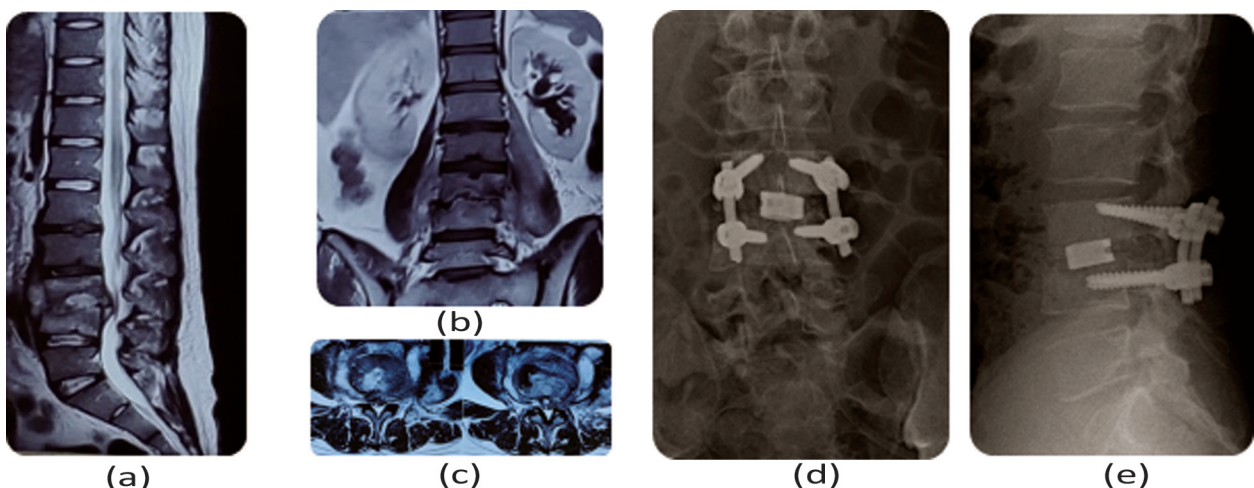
(a, b, and c) shows T2-weighted MRI images of the L3-L4 level disc and vertebral body destruction with anteroposterior and lateral translation. Figure 3 (d and e) shows post-operative images following posterior approach debridement, inter-body fusion and instrumentation. (The patient was a 24-year-old male who presented with intractable back pain for 6 months, not relieved by conservative management. He was diagnosed with a case of MRSA Spondylodiscitis.)
